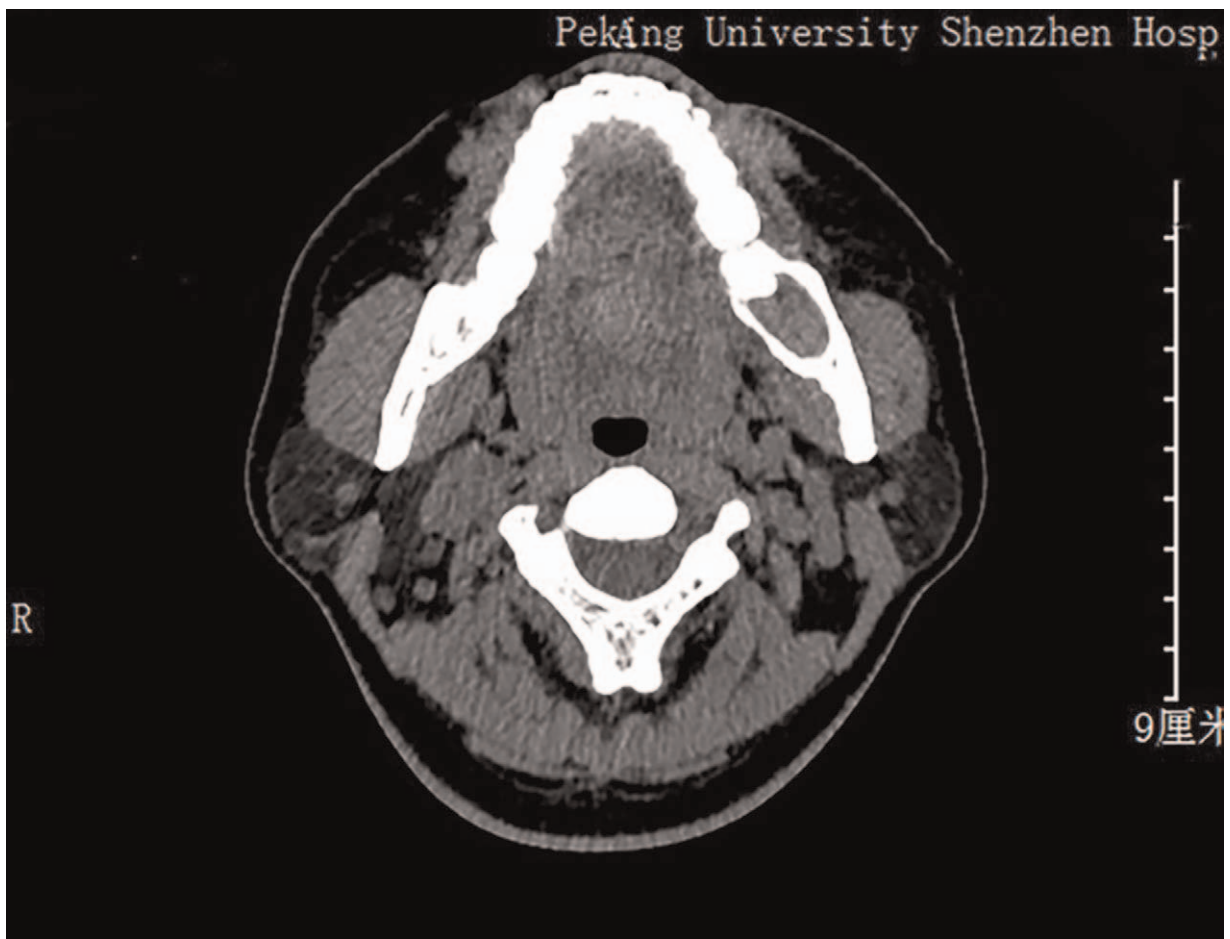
Computed tomography showed that the left mandibular bone was not dilated, and a 24 mm × 17.5 mm × 43 mm unilocular lesion without cortical erosion in the left mandible.
